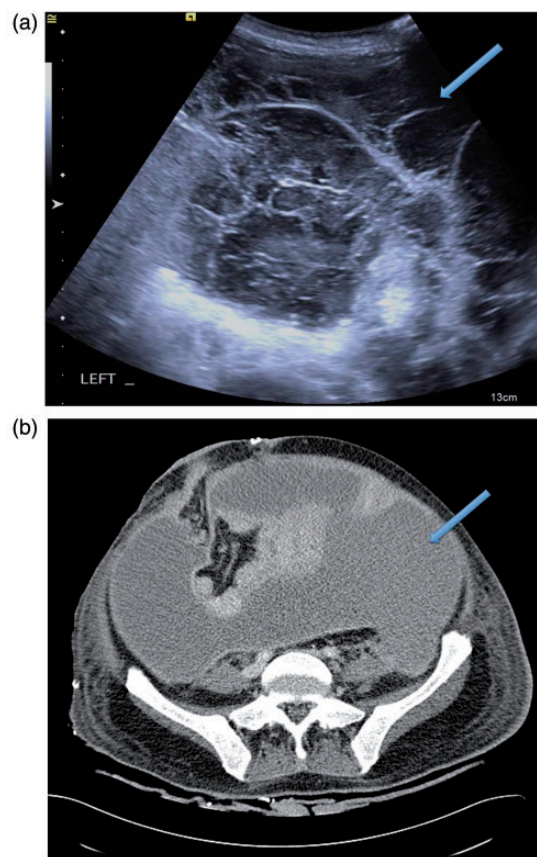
(a) An axial US image through the abdomen demonstrating complex ascites (arrow). Particulate debris and internal septations are a feature of exudates. Note qualitative role of US. (b) Contrast-enhanced axial CT image: Corresponding CT image in same patient showing a bland, homogenous low attenuation of fluid (arrow) on CT. Note US superiority at showing the complex nature of ascites.^{1,2}
